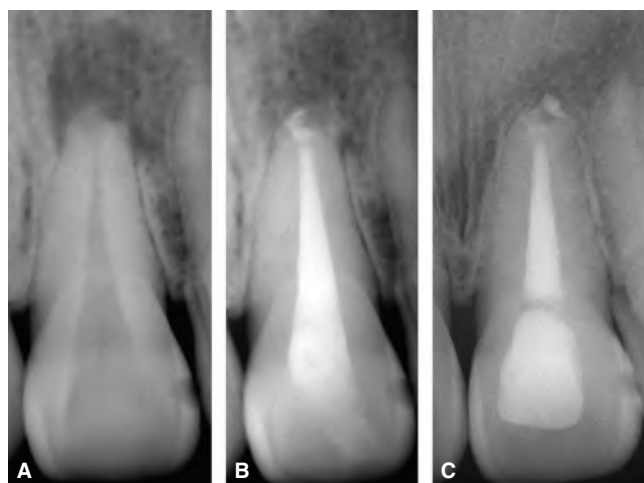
Endodontic treatment in a maxillary central incisor of a 25-year-old female. The patient reported to have suffered a traumatic injury to the tooth several years earlier. A. Preoperative radiograph showing periapical radiolucency and apical root resorption. B. Immediate postoperative radiograph. C. 17-year follow-up radiograph. Evidence of sealer remnants can still be observed. The periapical radiolucency has resolved and the tooth restored to function.
